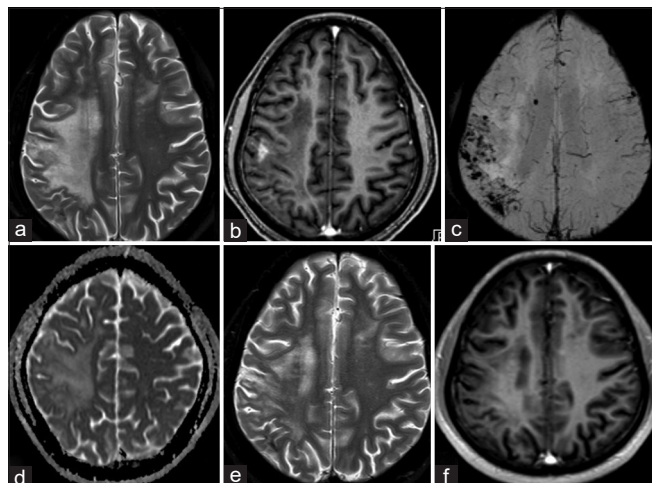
A 32-year-old female with vasculitis. Baseline axial T2W MRI (a) shows an ill-defined hyperintense lesion in the right centrum semi-ovale, with a single focus of macronodular enhancement (b). Numerous microhemorrhages showing “blooming” are noted on SWI (c). Follow-up MRI brain (d-f) after 5 months of steroid therapy showed a significant interval decrease in the T2W hyperintense areas and resolution of the enhancement. SWI: Susceptibility-weighted imaging.
